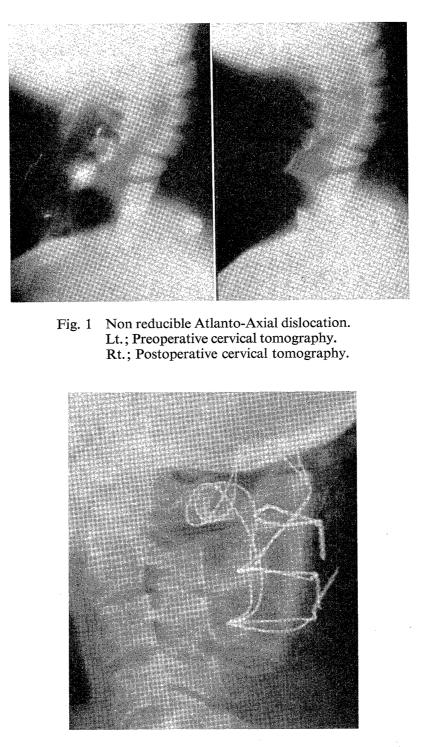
Occipito-Vertebral Fusion; Postoperative plain cervical roentgenography.
